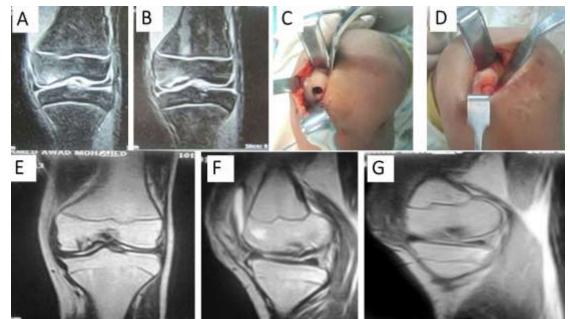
A 16 ys. old patient, with a symptomatic unstable OCD. of MFC, with no history of trauma. The preoperative Lysholm score was 52. (A,B) Preoperative MRI. (C,D) Mini-arthrotomy view of prepaired defect and graft. (E-G) Postoperative MRI, 11 months postoperatively. Final Lysholm score was 89 and rated good.
